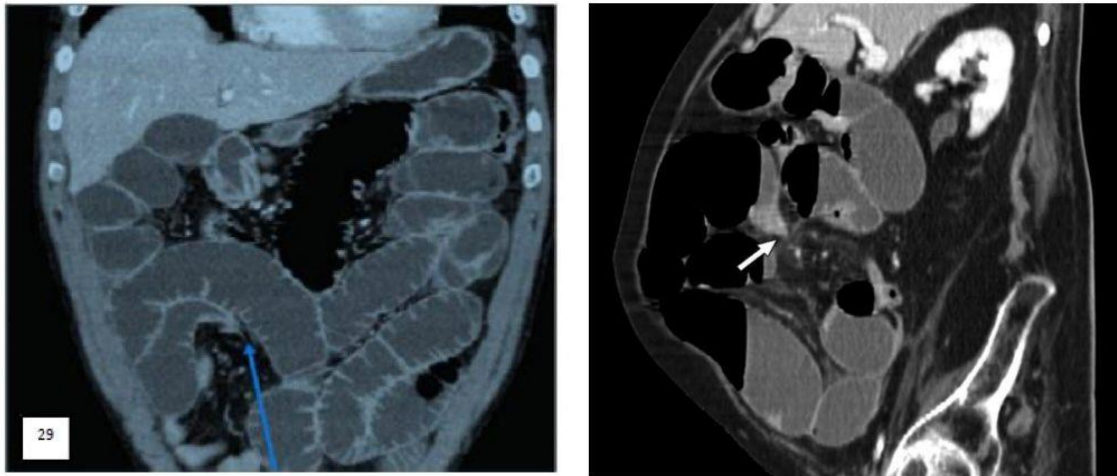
CT scan showing small bowel obstruction with suspected adhesive band
